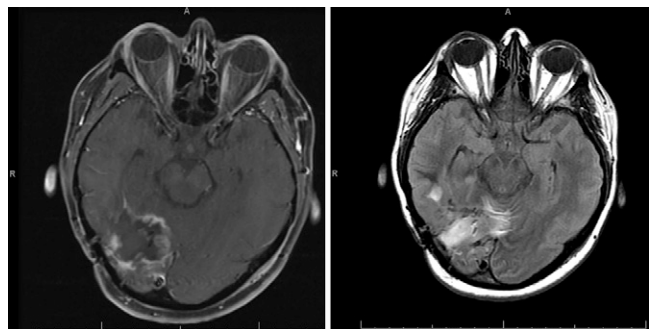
Post-thermal ablation. Left: Axial postcontrast T1-weighted MRI showing reduced enhancing tumor. Right: Axial T2-weighted fluid-attenuated inversion recovery MRI showing cesium seeds as well as edema around ablation site immediately postoperatively.
